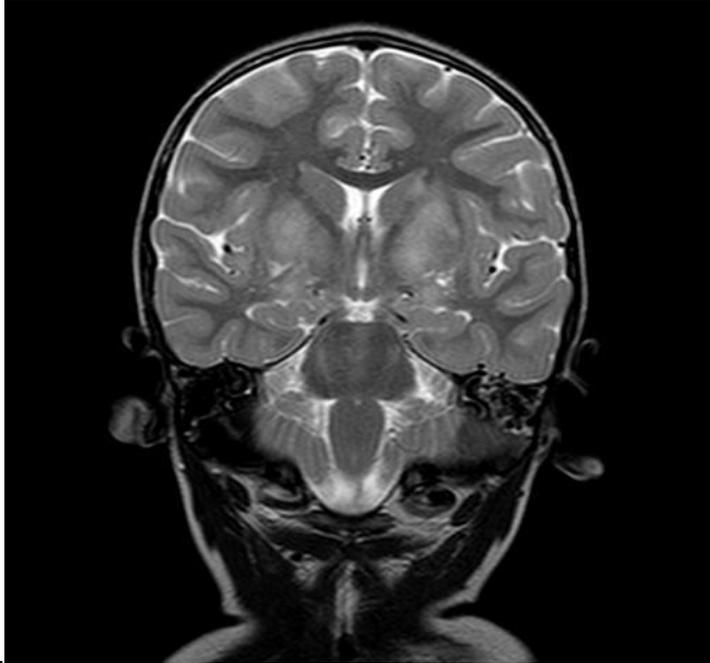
Immunoglobulin infusion (400 mg/kg/d for 5 days) was made. Clinical improvement. Negative brain MRI control after 2 months.
